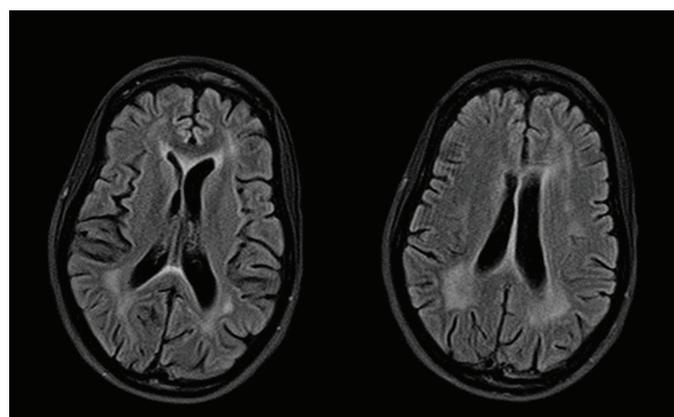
MRI showing patchy areas of periventricular T2 hyperintensity sparing the subcortical U fibers and associated parenchymal volume loss
